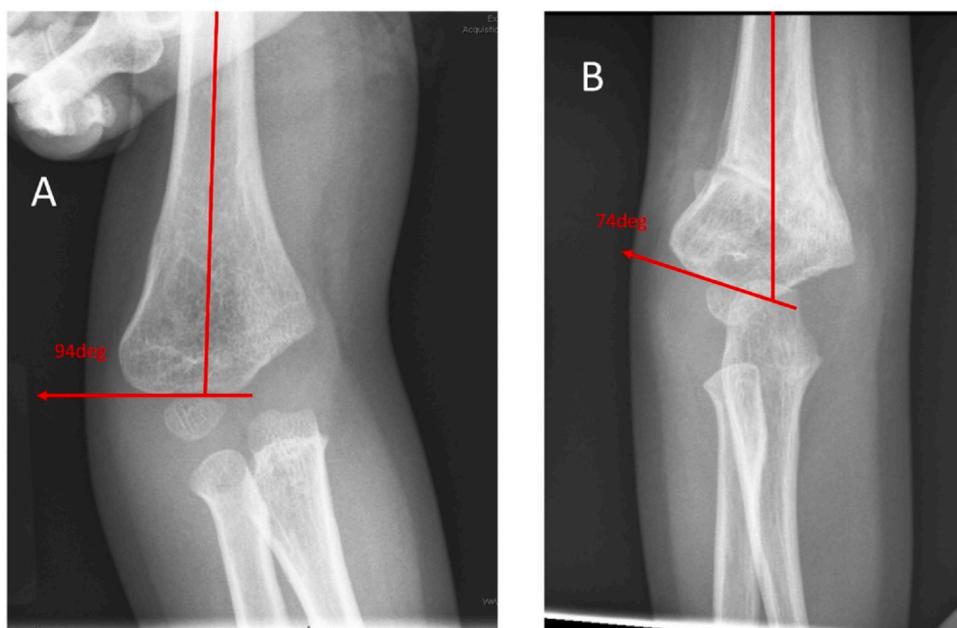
Radiographic measurement of Baumann's angle preoperatively (A) and postcorrection (B).
